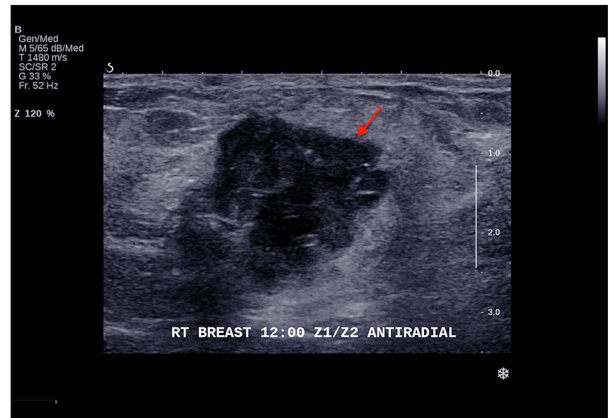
Breast ultrasound showing a single heterogeneous irregular hypoechoic mass (indicated by a red arrow) in the right breast, located at the 12 o'clock position, 1.5 cm from the nipple, and measuring $2.1 \times 1.9 \times 2.1$ cm. The mass was associated with internal and peripheral vascularity with inner calcifications. It showed ductal extension with intraductal vascular components radiating and reaching the nipple, making it suspicious for nipple involvement. There was no axillary lymph node involvement.
